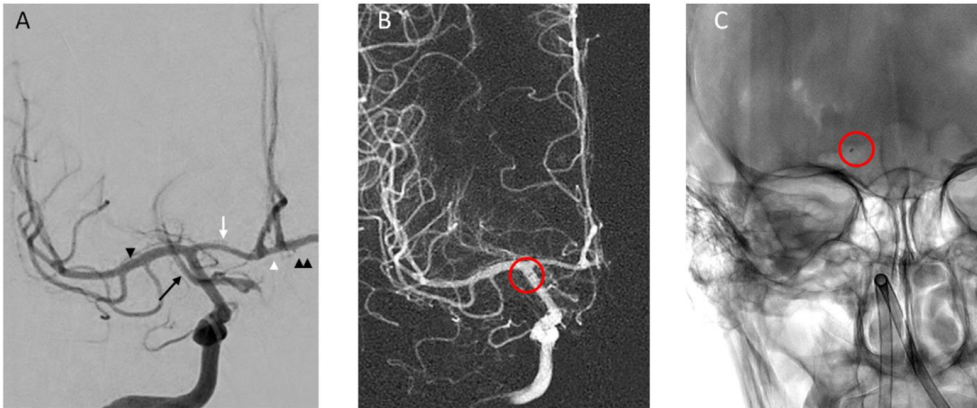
(A) Digital subtraction angiography, anteroposterior view. Black arrowhead, right middle cerebral artery; white arrow, right anterior cerebral artery; white arrowhead, anterior communicating artery; double arrowhead, left middle cerebral artery; black arrow, right posterior communicating artery. (B) Digital subtraction angiography, anteroposterior view: road-mapping; (C) Plain X-ray, anteroposterior view. Red circle, position of the tip of the microcatheter used for intracranial arterial pressure measurements.
